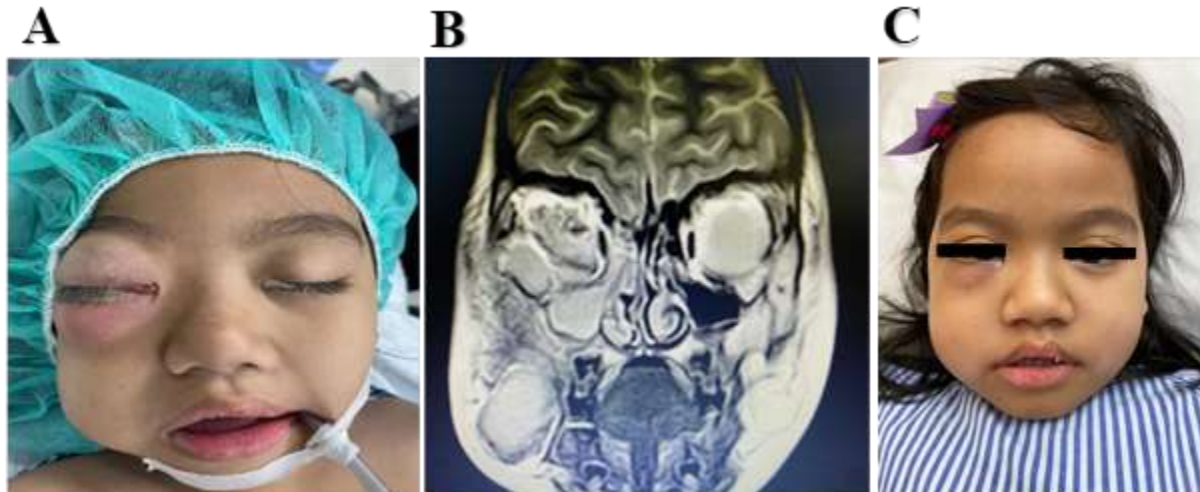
(A) A 4 year old patient with right orbital abscess extending to the lower lid and causing proptosis. (B) Computed tomography (CT) findings demonstrating contrast enhancement in intraorbital suspecting intraorbital abscess with orbital cellulitis, right pansinusitis and buccal abscess. (C) The same patient 7 days after endoscopic sinus surgery and antimicrobial therapy.
